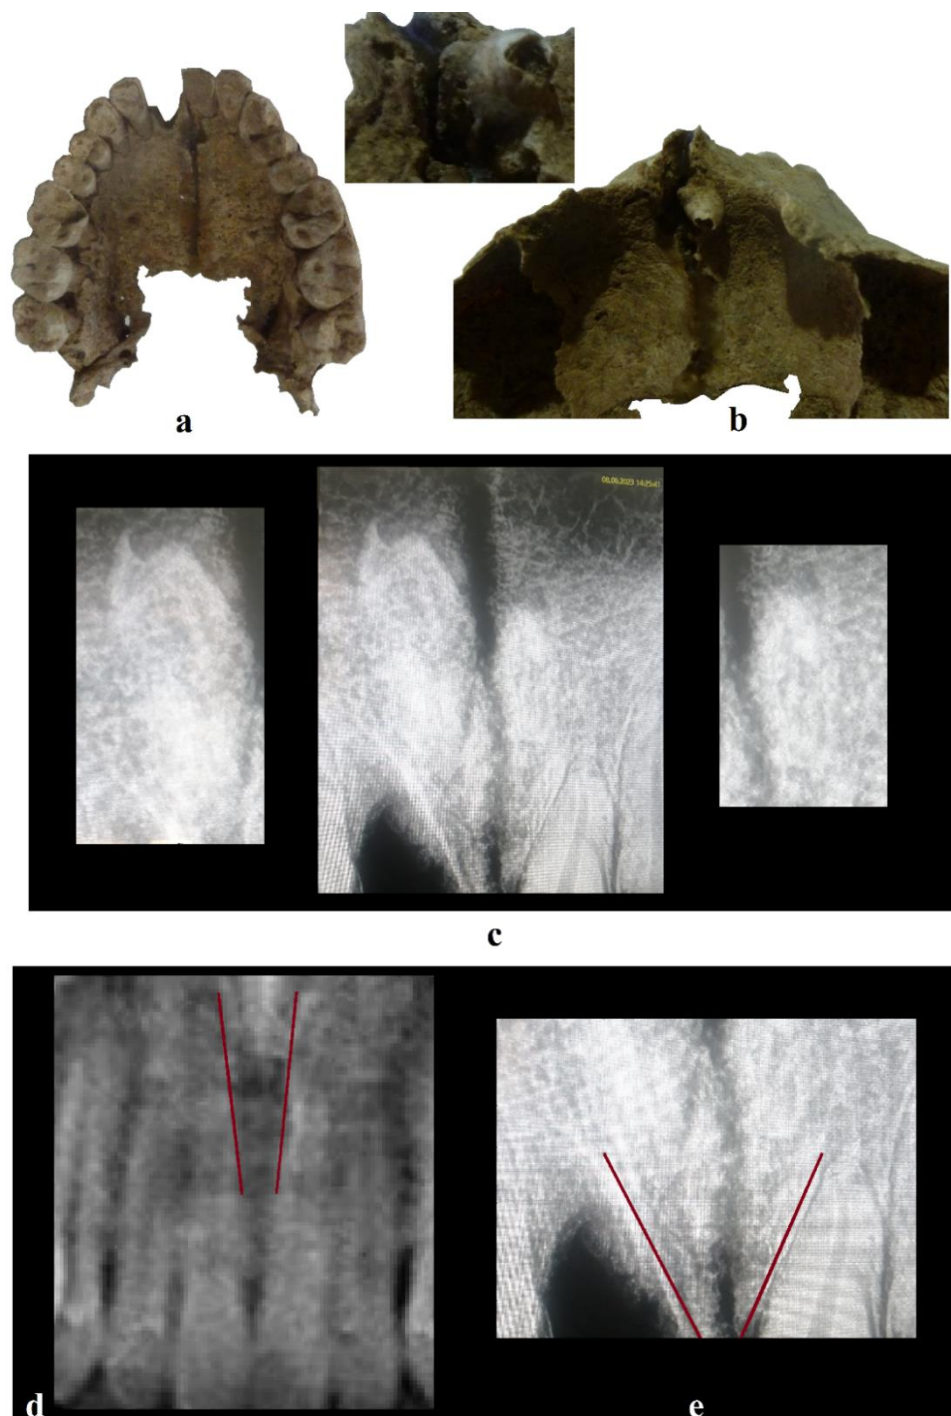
Intraoral dentition (a), location of the nasal tooth in the maxilla (b), radiographic investigations (c), lateral displacements of the alveolar (tooth) socket of the medial incisors are observed (e), normal alveolar (tooth) socket of the medial incisor (d).
